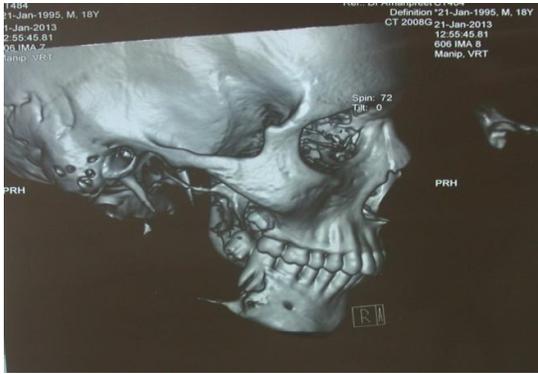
CT scan showing extent of bony destruction
